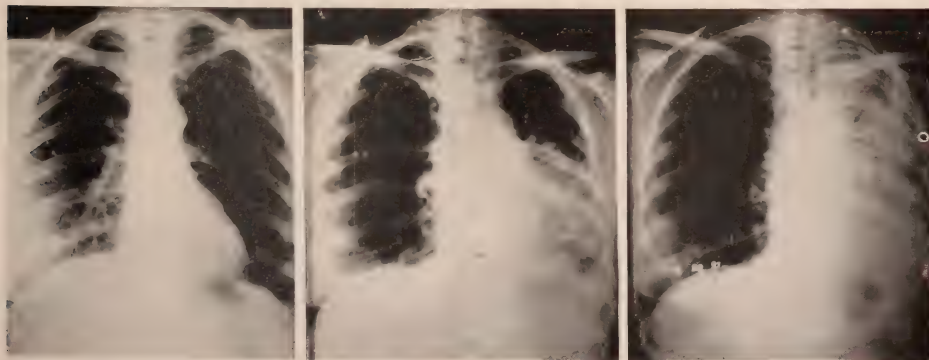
Case No. 14520—Miss S. F.—(1) Roentgenogram made at time of admission, before treatment was given, showing no increase in density in the left lung. (2) After treatment was given, showing
